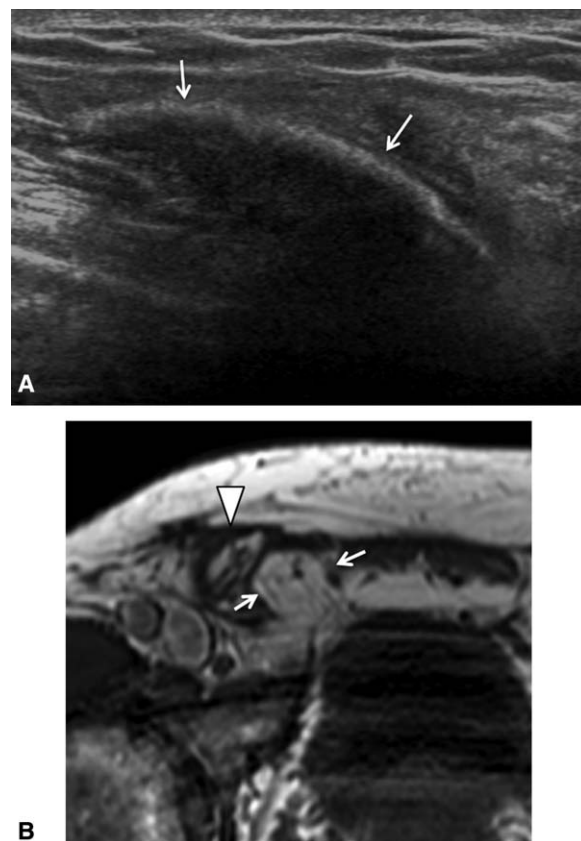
(A) Transverse sonogram of the right groin of a patient who had previously undergone repair of a direct inguinal hernia. Acoustic shadowing from the surgical mesh (arrows) largely obscures the assessment of any residual or recurrent hernia located deep to the mesh. (B) Axial T1-weighted MRI from the same patient shows a recurrent direct-type inguinal hernia (arrows) located deep to the surgical mesh (arrowhead). This hernia contains fat and no bowel.
